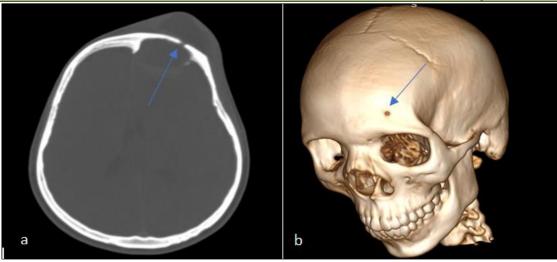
Head CT, bone window, axial plan (a) and 3D reconstruction (b) showing bulging of the cortical bones with bone erosion of the walls frontal sinus, and a petrous channel (blue arrow) communicating the mucocele with the empyema
